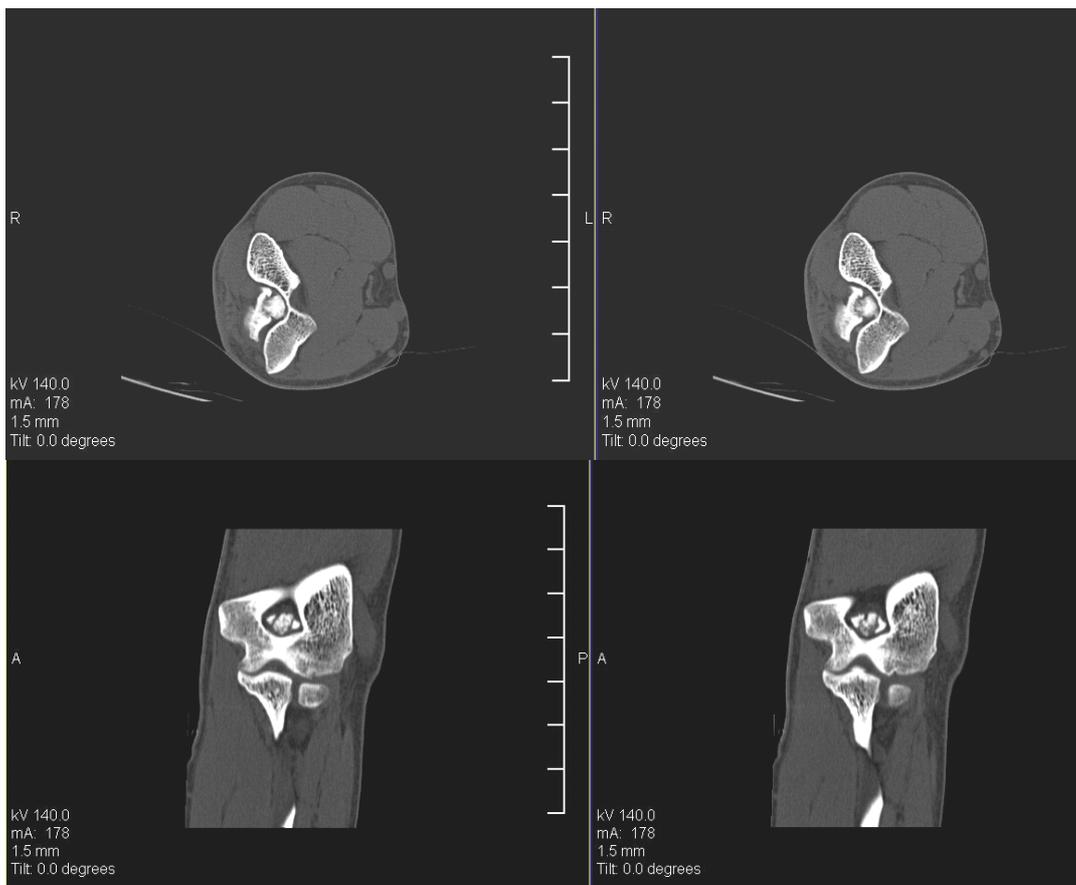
CT scan examination of the olecranon
